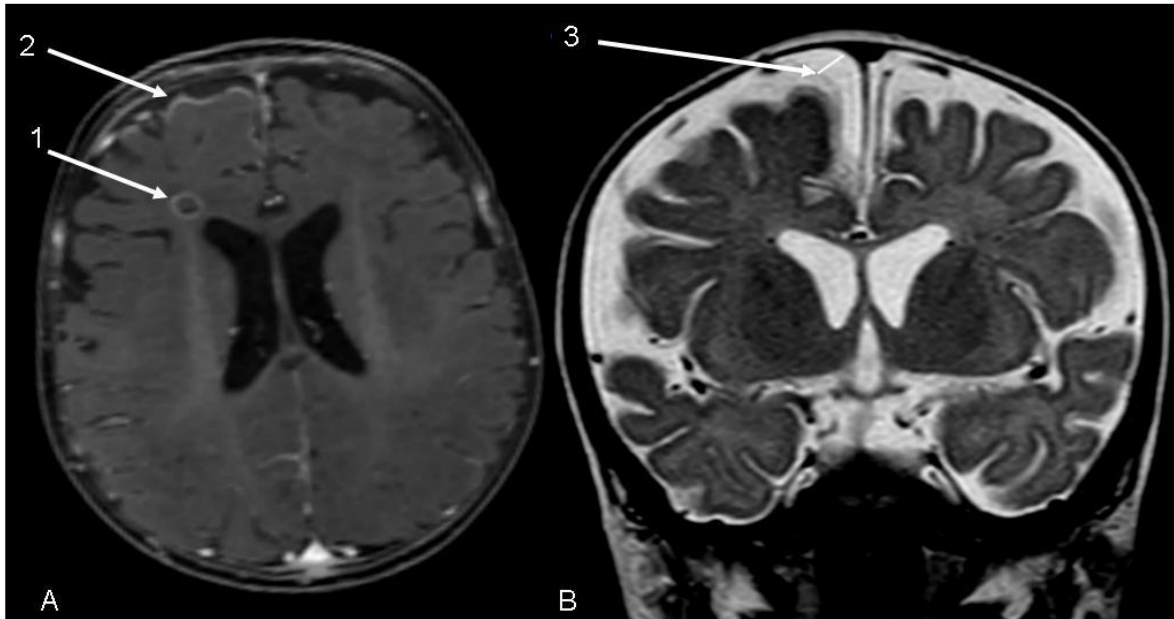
A, T1-weighted with gadolinium brain MRI shows an 8x6 mm frontal cerebral abscess (1) and meningeal enhancement (2); B, T2-weighted imaging shows a 6 mm subdural empyema (3)
